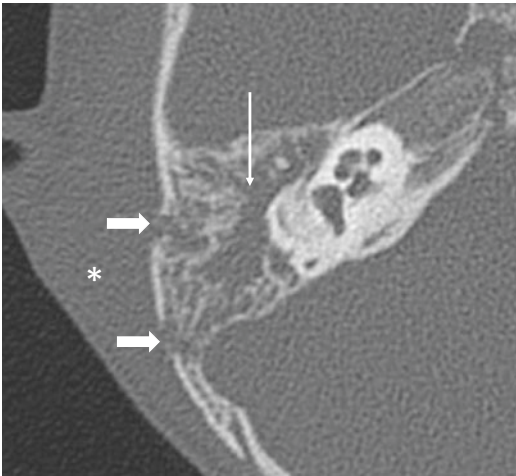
Axial CT bone window showing complete opacification of the right mastoid air cells (narrow arrow), outer cortical bony erosions (thick arrows) and overlying soft tissue swelling (asterisk)
